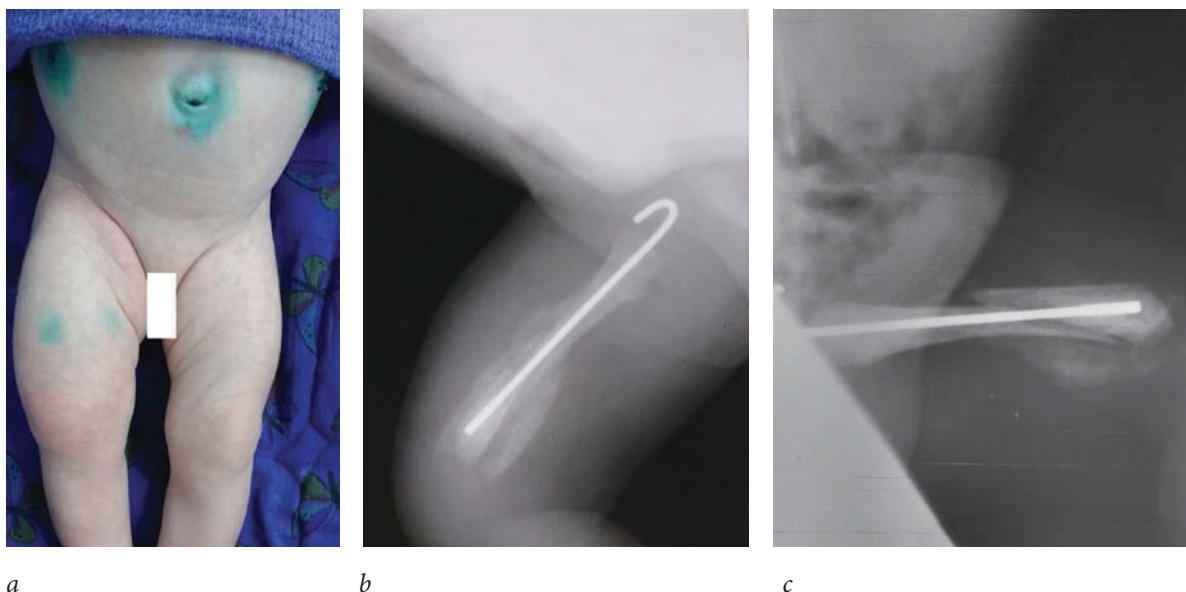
Newborn K., 21 days. The axis of the right and left hips (a). X-rays of the right femur in two projections (b, c)
